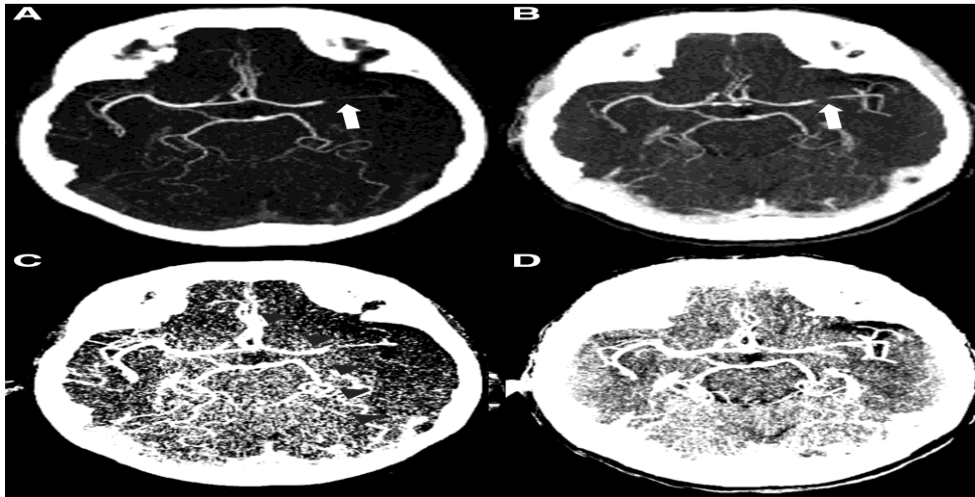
Early arterial (A and C) and delayed phase, 80 seconds after injection (B and D). Computed tomography angiograms demonstrating the difference in the appearance and length of thrombus depicted at different phases (A and B, white arrows). Additionally, images rewindowed to assess for ischemia (C and D) show that the early arterial imaging overestimates the degree of hypodensity (black arrowheads) relative to the delayed imaging.
